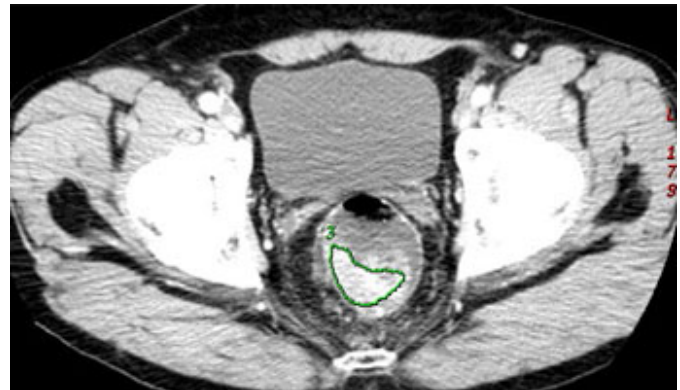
Axial contrast enhanced CT image of the pelvis shows rectal cancer as an irregular enhancing mass in the rectum causing wall thickening (outlined in green).
